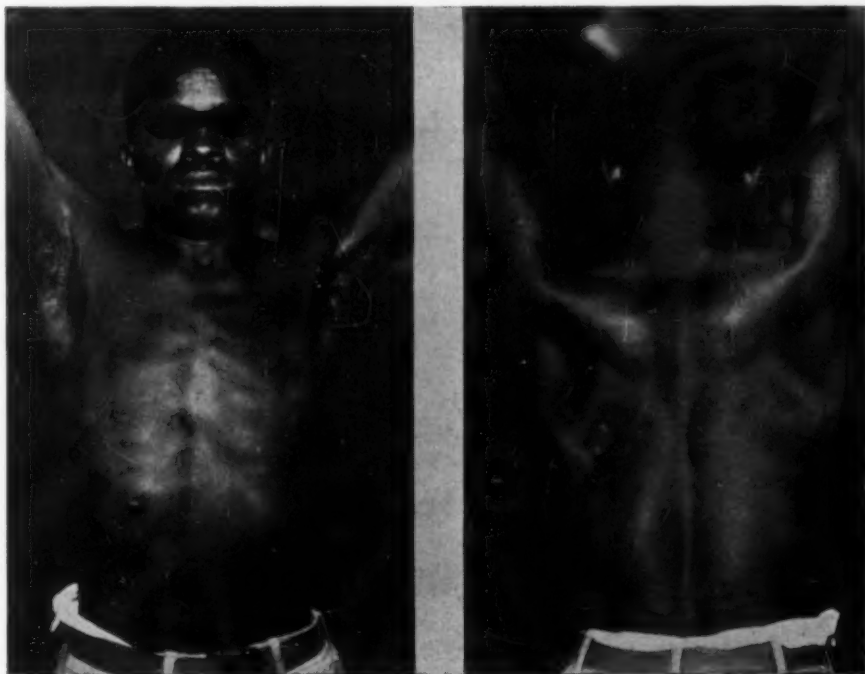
Anterior and posterior views of the patient whose x-ray photograph was shown in Figure 5. Note collapse of chest wall over former site of empyema cavity. There is no apparent loss of function.
